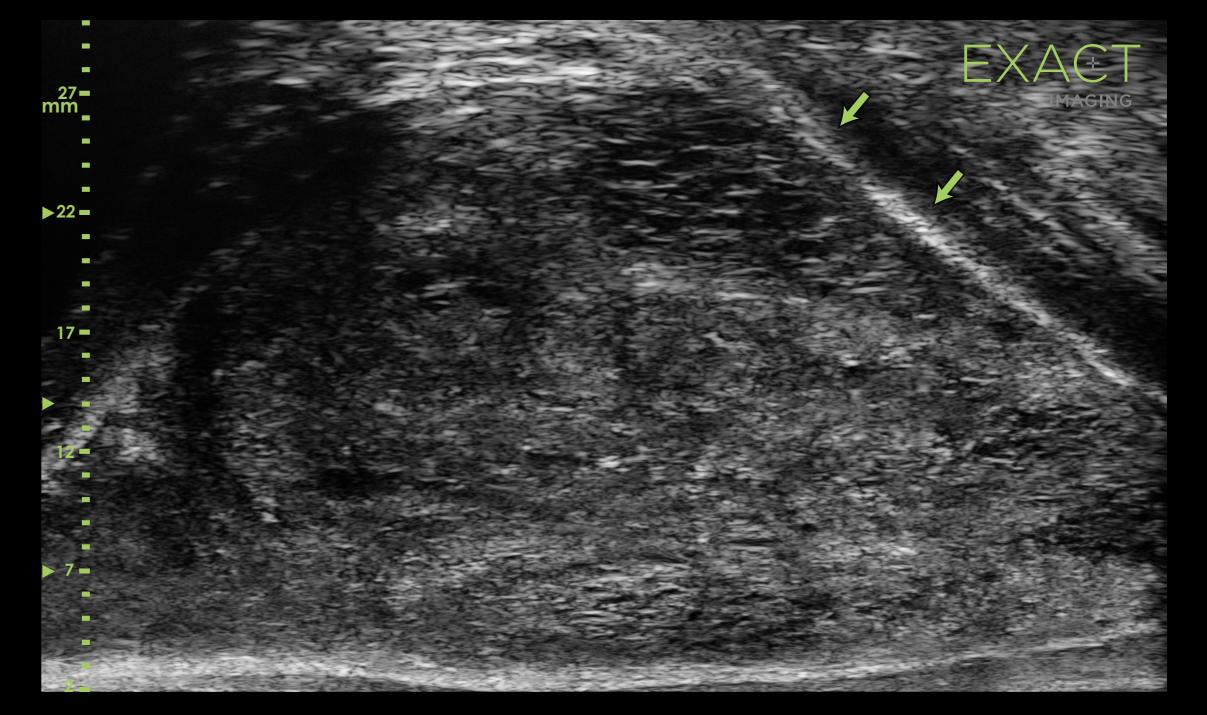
Sonographic findings in a patient with EPE and thick irregular halo compared to cancer-free contralateral lobe. Images A and B from same patient showing (A) irregular thick hypoechoic halo along anterior border of the left lobe (red arrows) with confirmed cancer by RP. (B) Right lobe, with no cancer as per RP, showing a thin hypoechoic halo (green arrows).
